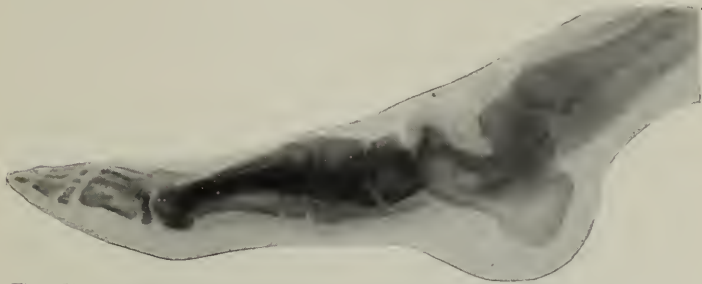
Radiograph of a Right Foot showing a Medium Degree of Flat-foot, viewed laterally.
